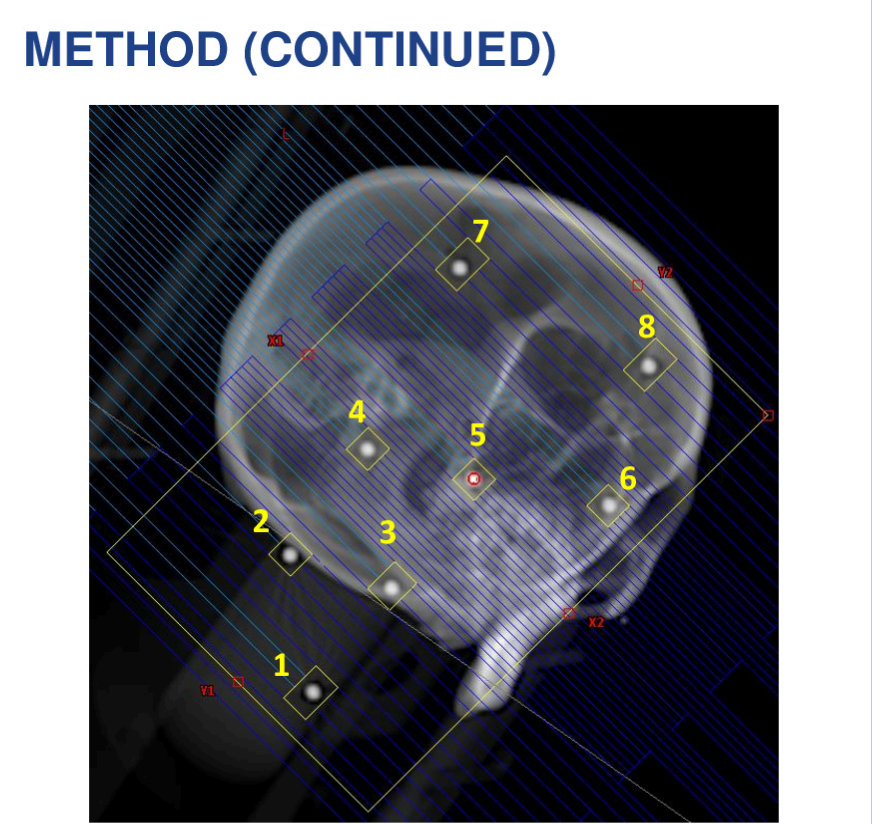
A digitally reconstructed radiograph (DRR) of one of the treatment fields (Gantry=225°,Table=315°,Couch=315°) showing a total of 8 targets exposed to rectangular fields. Isocentre location coincided with target 5.
